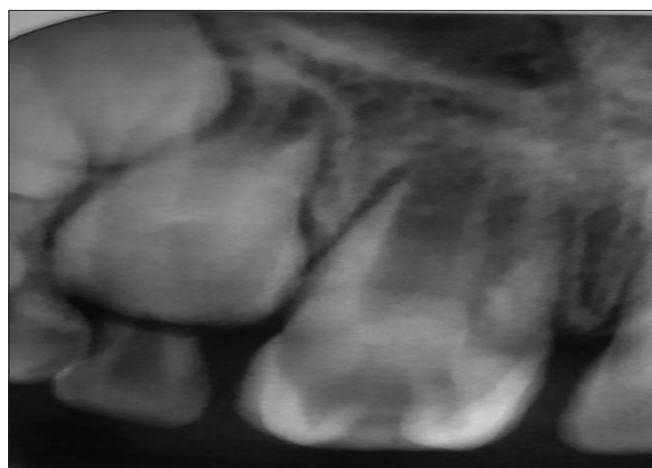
Intraoral periapical (IOPA) Radiograph showing V-shaped inverted radio-opaque structures pointing towards the incisal edge separated from deep groove
